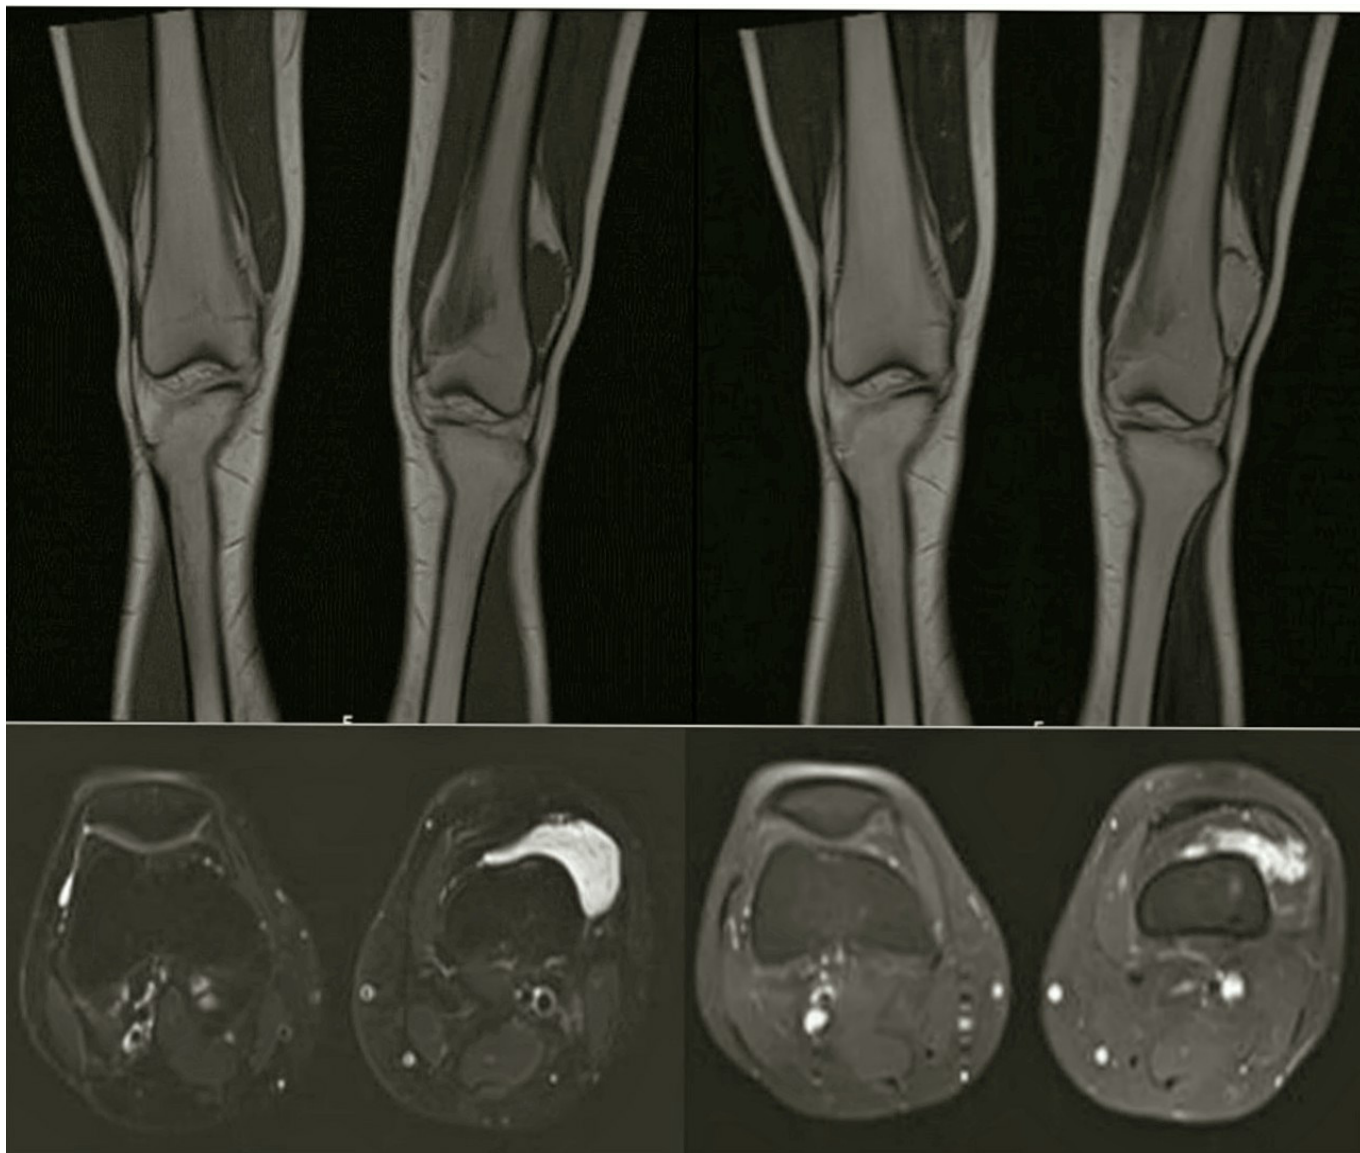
The intra articular nodular soft tissue mass filling the suprapatellar bursa was seen T1-weighted image isointense, T2-weighted image hyperintense, fat-suppressed T2-weighted image hypointense and had contrast enhancement.
